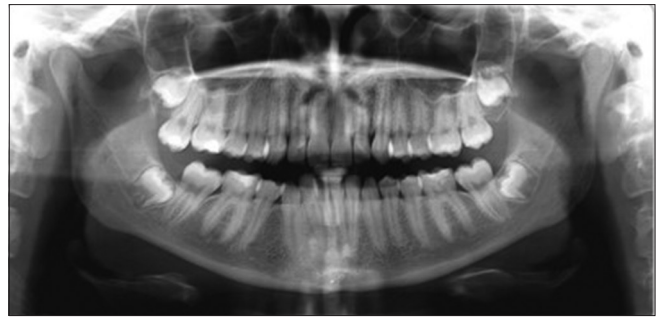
Panoramic radiography meeting the inclusion criteria for split-mouth study
